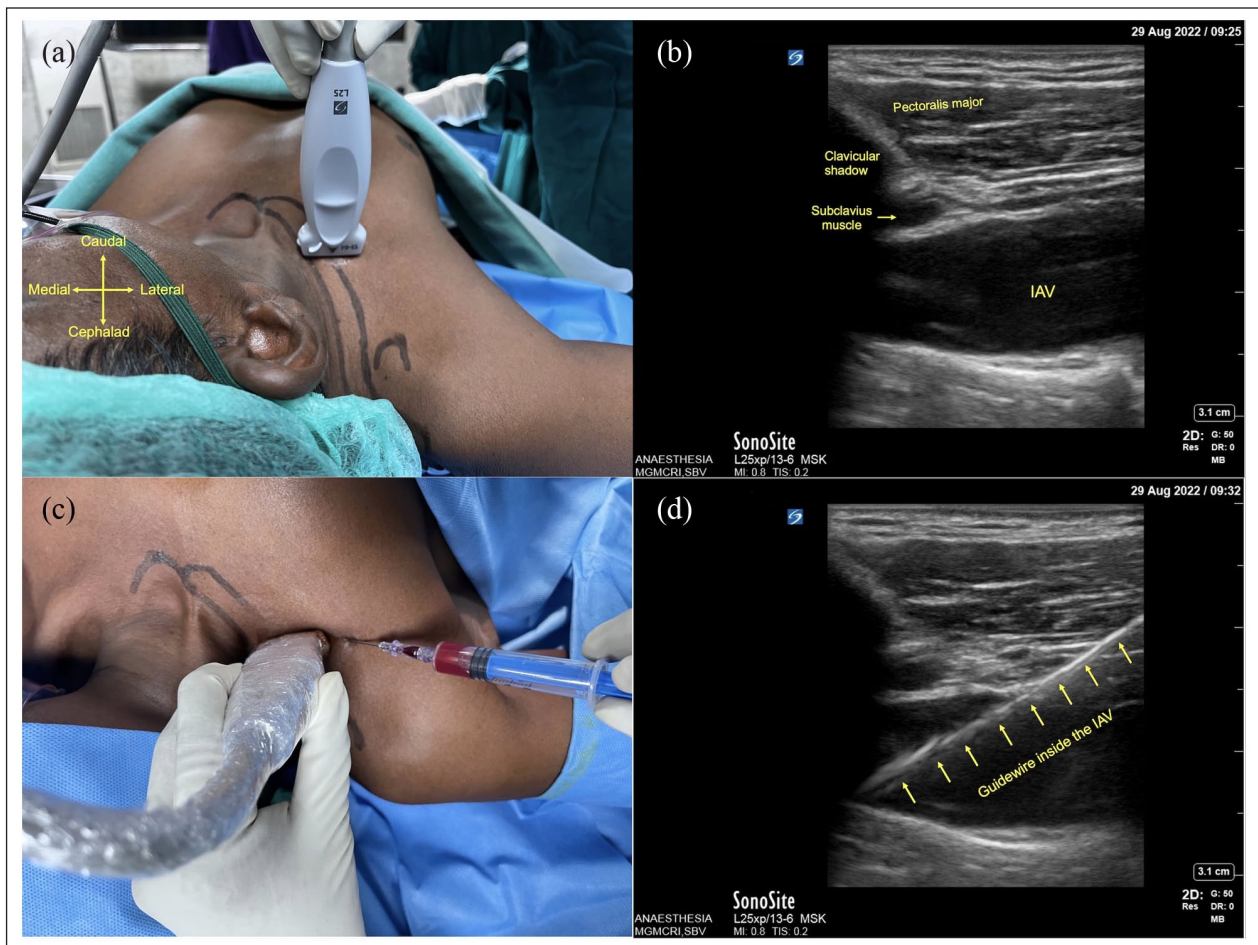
Patient and sonographic images related to in-plane cannulation of the infraclavicular axillary vein. (a) Ultrasound probe position over chest wall. (b) Sonographic image of the right IAV. (c) Needle puncture of IAV with aspirate of venous blood. (d) In-plane visualisation of guidewire inside the IAV. IAV: infraclavicular axillary vein.
